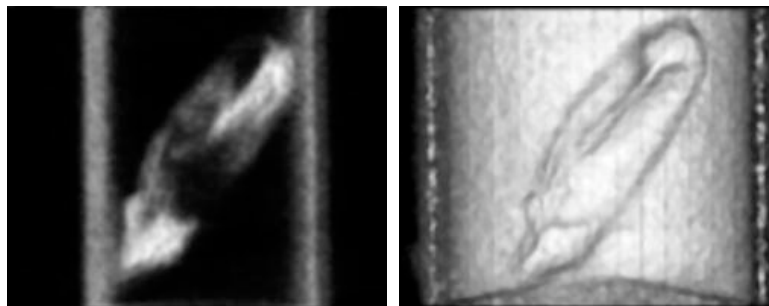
CT images of the dried egg (left : longitudinal cross sectional view, right : 3D image).
